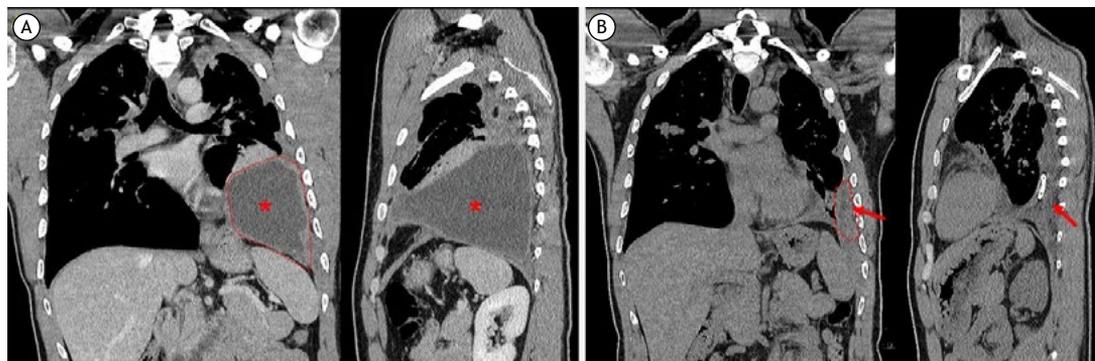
Chest CT (coronal and sagittal) before intrapleural therapy, showing the presence of moderate left loculated pleural effusion (red asterisk and dotted line) (A). Chest CT (coronal and sagittal) after intrapleural therapy, showing the pigtail catheter and a significant reduction in pleural effusion (red arrow and dashed line) (B).
